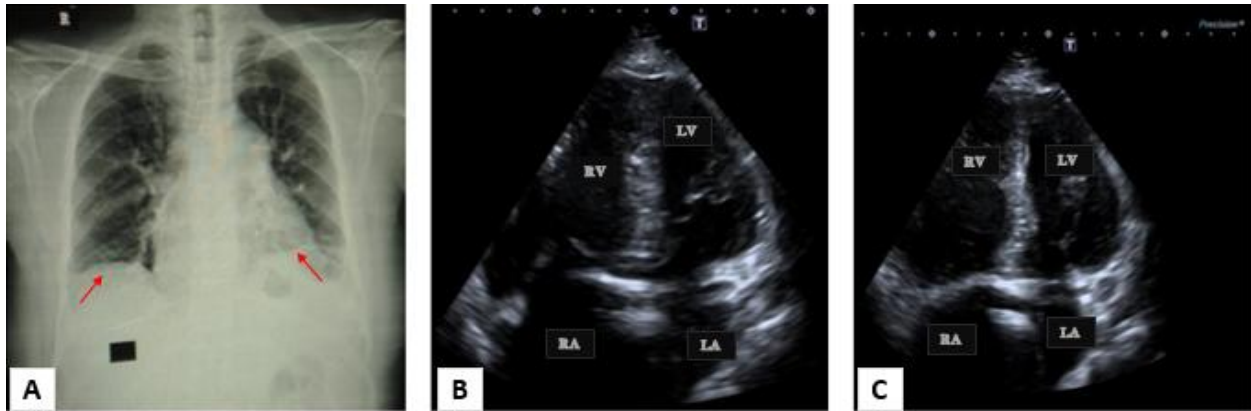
(A): The chest x-ray showed signs of vascular congestion and both hemi-diaphragms were aligned at the same level (indicated by red arrows). (B and C): Echocardiography revealed severe pulmonary artery hypertension with elevated pulmonary artery systolic pressure (PASP-110 mmHg), along with moderate tricuspid regurgitation. The right-sided cardiac chambers appeared dilated, while the left ventricle showed a “D-shaped” configuration, indicating increased pressure in the right ventricle.
